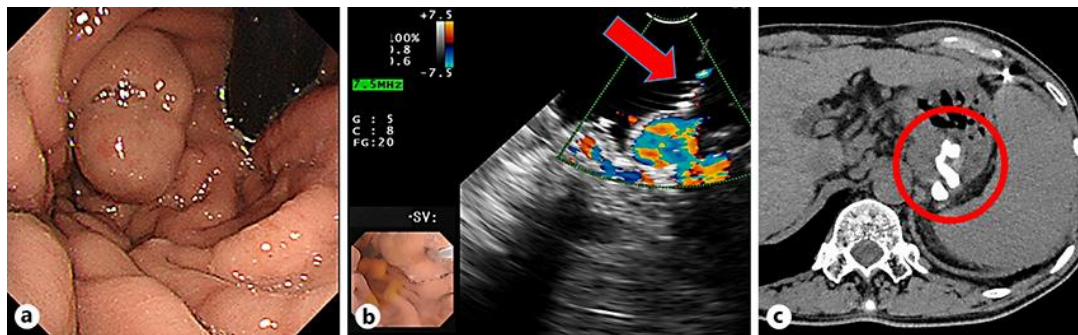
a Endoscopic findings before treatment of case 1. b Endoscopic ultrasound findings during treatment of case 1 (the arrow shows the needle puncture). c Abdominal computed tomography findings after treatment of case 1 (the circle indicates the site of successful treatment).
